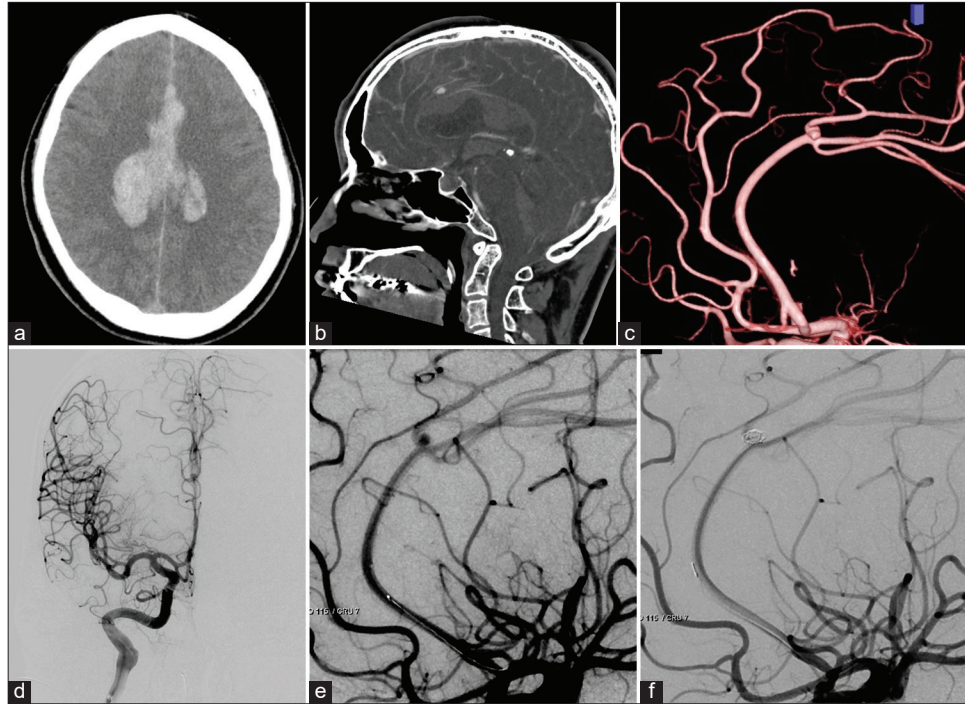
(a) Initial computed tomography (CT) of the brain showed intracerebral hemorrhage and subarachnoid hemorrhage in the cingulate gyrus. (b and c) CT angiography of sagittal view (b) and 3D digital subtraction angiography (c) showed a saccular aneurysm at the A3-A4 junction. (d and e) Right internal cerebral artery angiogram showed an accessory anterior cerebral artery and a saccular aneurysm. (f) Postoperative angiogram showed complete obliteration of the aneurysm.
